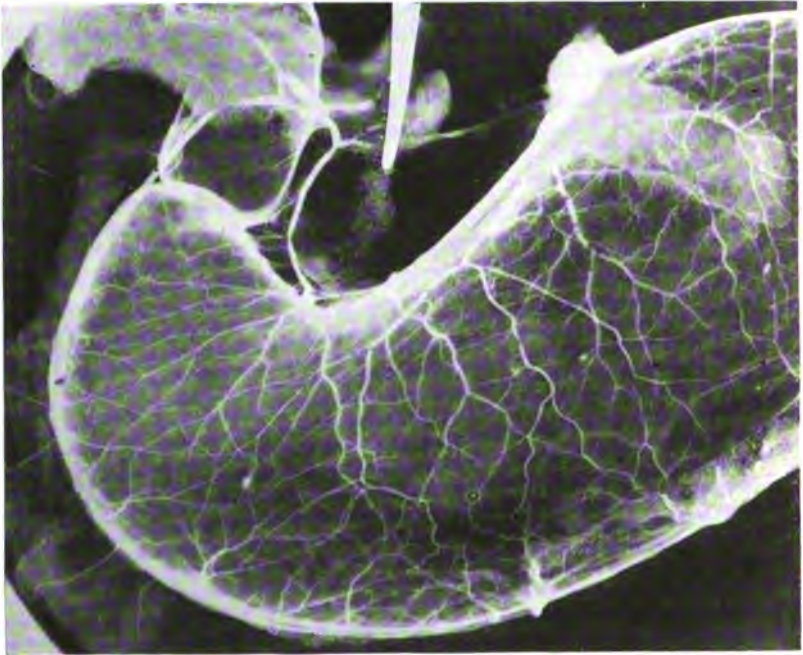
Stereoscopic roentgenogram. Vessels injected with gelatin-bismuth solution.
